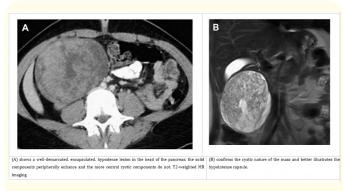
SPTP. Contrast-enhanced CT image.
